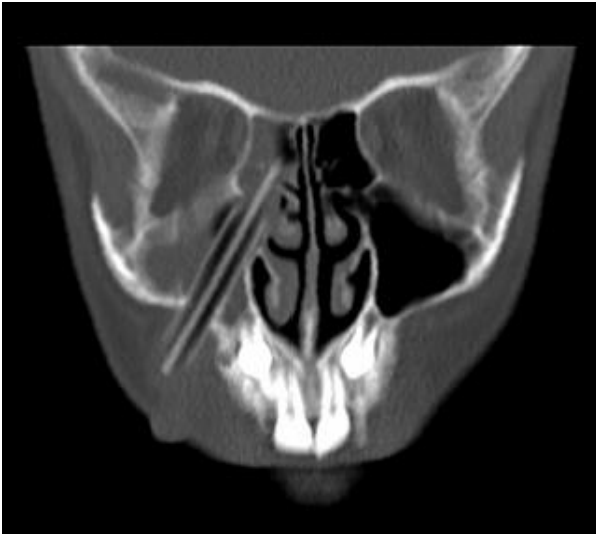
A tubular abnormality seen in CT scanning
